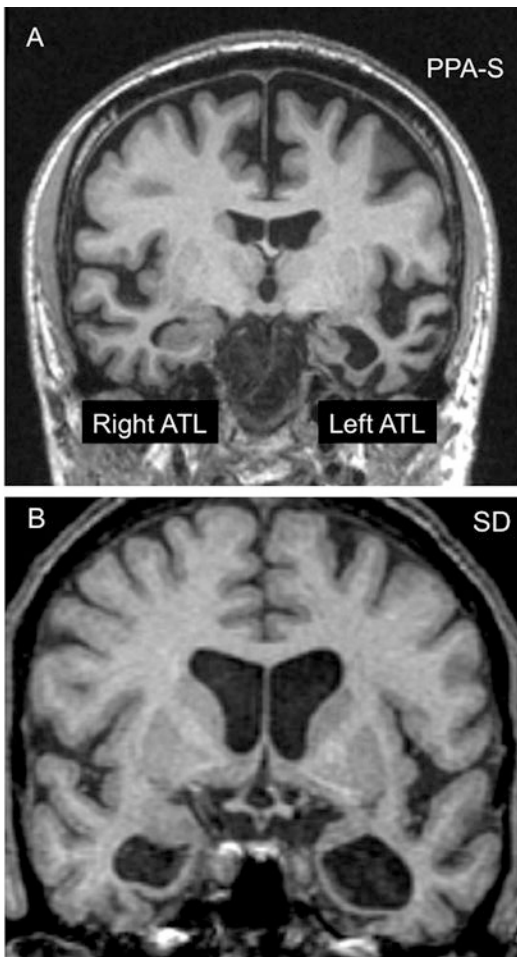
PPA-S versus SD. Figure 2a shows the MRI scan of a right-handed man with symptom onset at the age of 59. On examination, 7 years later, the clinical pattern was PPA-S and atrophy was much more prominent in the left anterior temporal lobe (ATL). At that time, he had severe word comprehension impairments but no difficulty with non-verbal object recognition either in testing or in everyday life. In comparison, Fig. 2b shows the MRI scan of a right-handed man with symptom onset at the age of 65. Three years later, at his initial visit, ATL atrophy was bilateral. He had prominent word comprehension and object recognition impairments. This combination led to a subsequent diagnosis of semantic dementia (SD)
